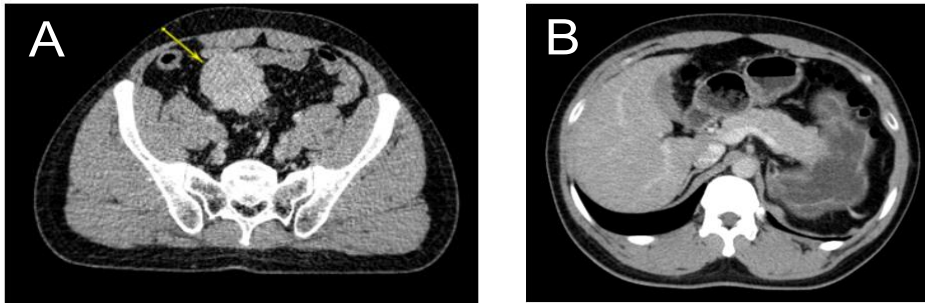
CT scan images: (1A) A contrast-enhanced tumor with a size of 50x65mm located at the hypogastric region (yellow arrow). (1B) Absence of the spleen in the normal position (left hypochondriac region)
